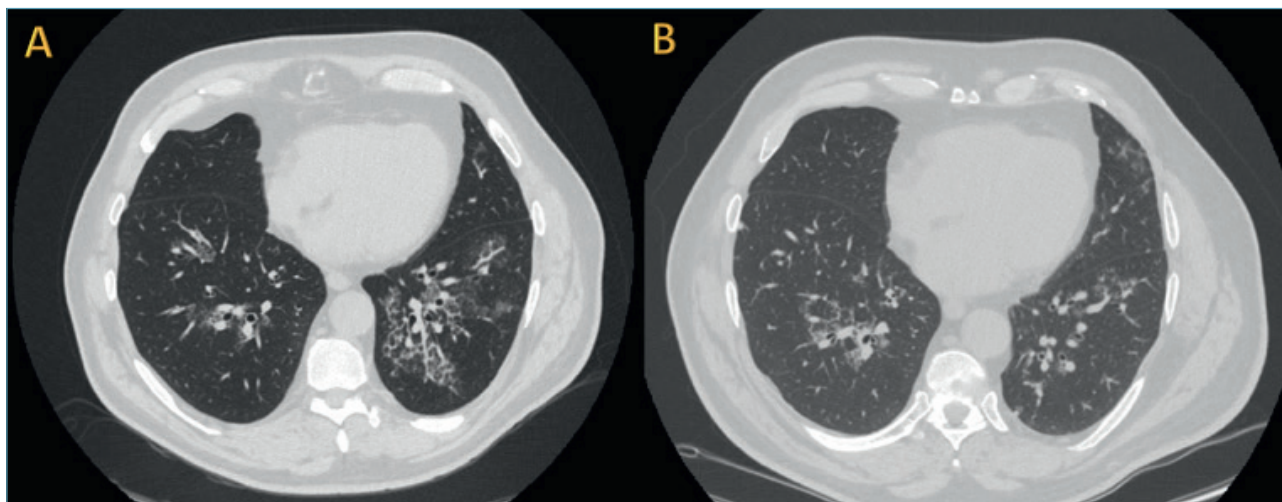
A) Thorax HRCT shows ground glass opacities in the right lower lobe and interlobular septal thickening in region of ground glass opacities representing “crazy paving” in the left lower lobe. B) Note the reduction of opacities specially in the left lower lobe after treatment.
